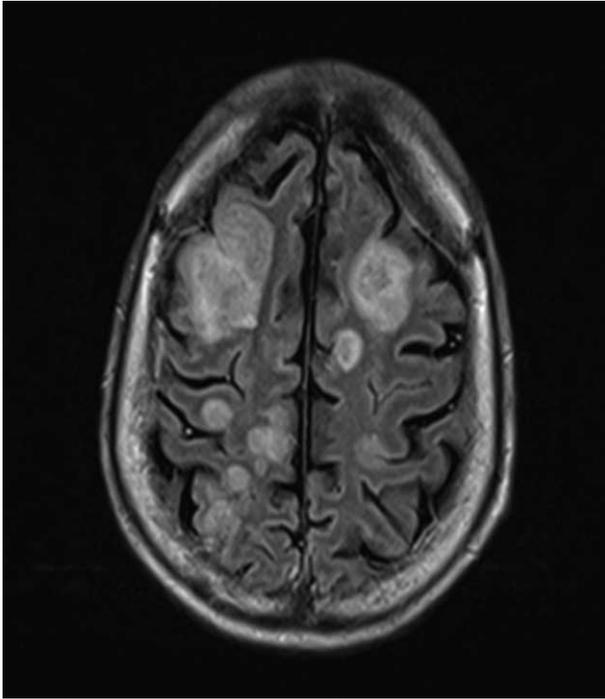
Magnetic resonance imaging showed multifocal parietal lesions with hemorrhage in the brain (arrows).
